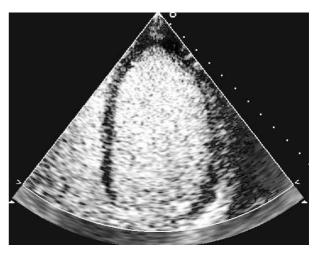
Frame of Contrast Echocardiography. The U-shaped structure is the myocardium to be segmented.
